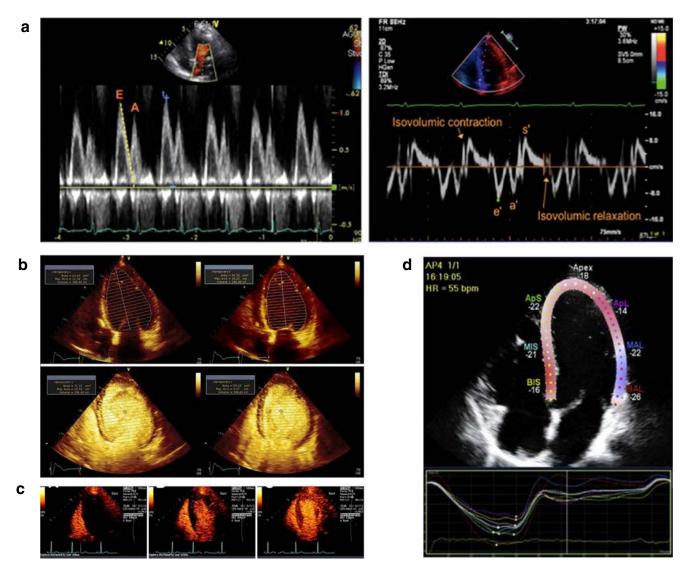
Echocardiography of LV diastolic function. a Doppler transmitral flow demonstrating early (E) and late/atrial (A) waves on pulsed-wave Doppler at the mitral leaflet tips in the apical 4-chamber view (left). Pulsed-wave tissue Doppler velocities at the lateral mitral annulus (e' = early diastolic, a' = late/atrial diastolic, and s' = systolic tissue velocities) (right). (Reprinted from Mitter et al. [45]). b Differences in end-diastolic/
